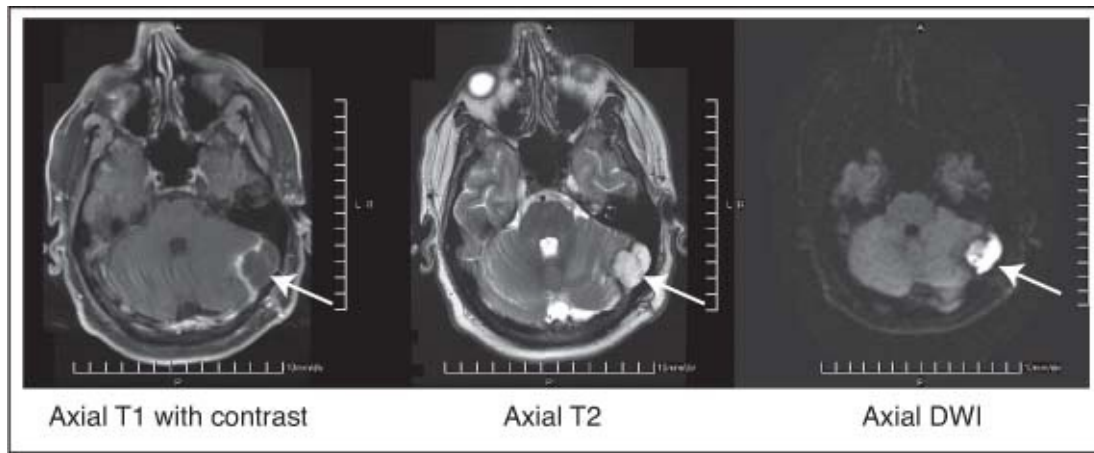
MRI demonstrating left cerebellopontine angle epidermoid Note that the CSF is dark on the DWI
